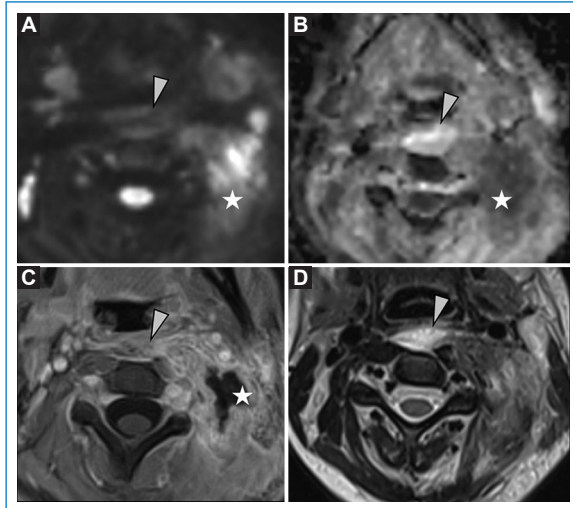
A and B: Siemens 1.5 T Axial RESOLVE diffusion. C: T1-weighted image after gadolinium. D: T2-weighted SE image. Left paravertebral lymphadenopathy, suppurative or abscessed with central purulent content, showing diffusion restriction and peripheral capsular enhancement (star). Retropharyngeal edema/phlegmon. Occupation of the retropharyngeal space by contents (arrowhead) with facilitated diffusion, mild enhancement, and high T2 signal. This avoided a surgical intervention of the retropharyngeal space.
